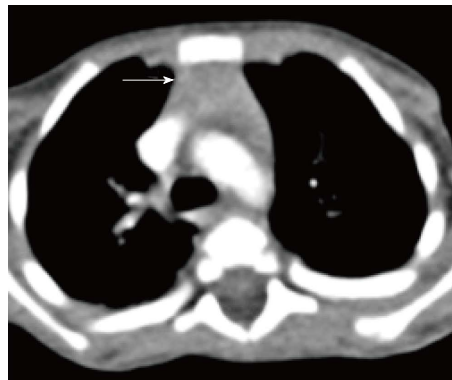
Normal appearance of the thymus on computed tomography scan of a 3-year-old boy. Axial contrast-enhanced computed tomography section shows homogenous soft tissue density structure (arrow) in the anterior mediastinum. Note that there is no compression of the vascular structures or airway.
